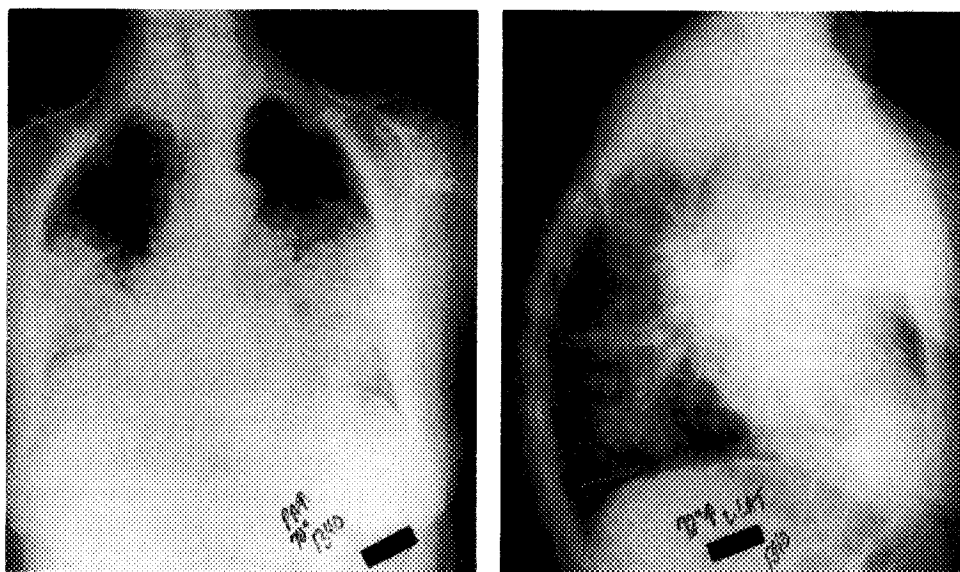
PA chest X-ray demonstrating peri-hilar opacities with sparing of the apices and bases.
